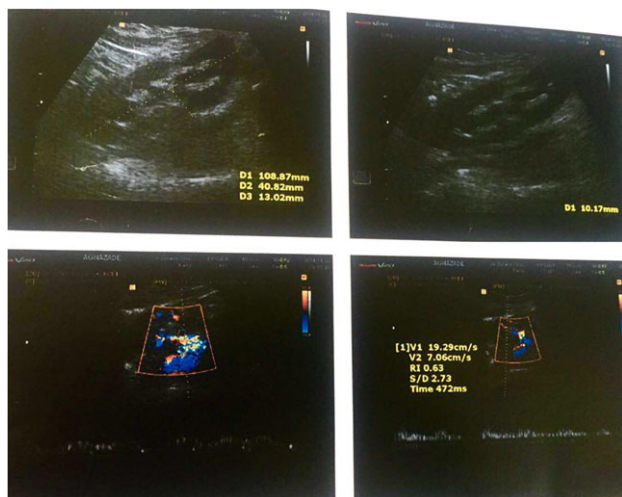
Color Doppler ultrasound of the transplanted kidney 2 months after surgery.
